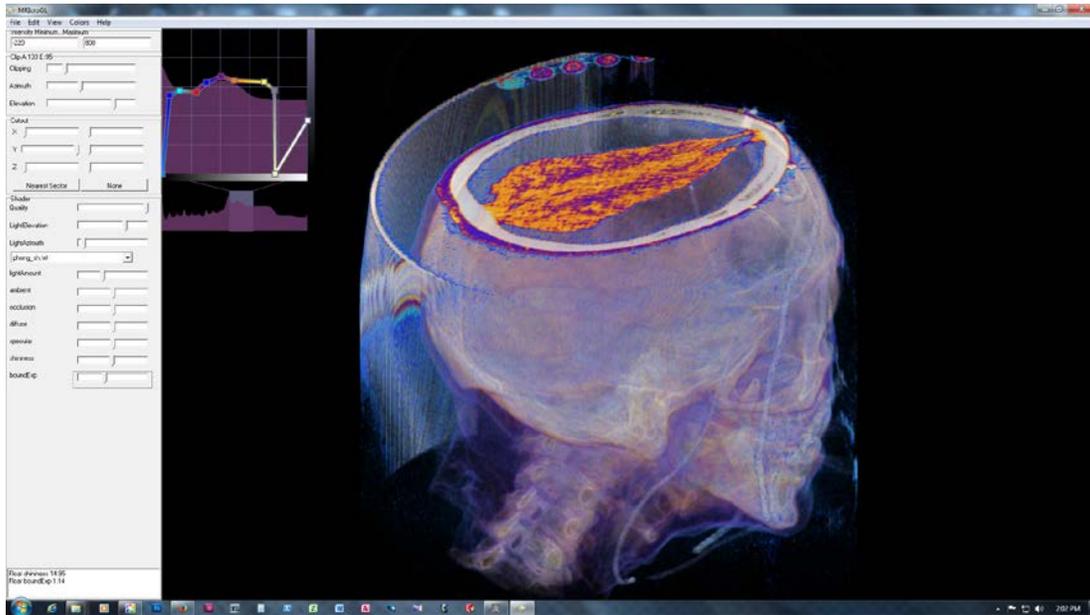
A CT scan clearly reveals the size and shape of a cryoprotected brain inside the skull, and also differentiates between frozen and vitrified areas.
